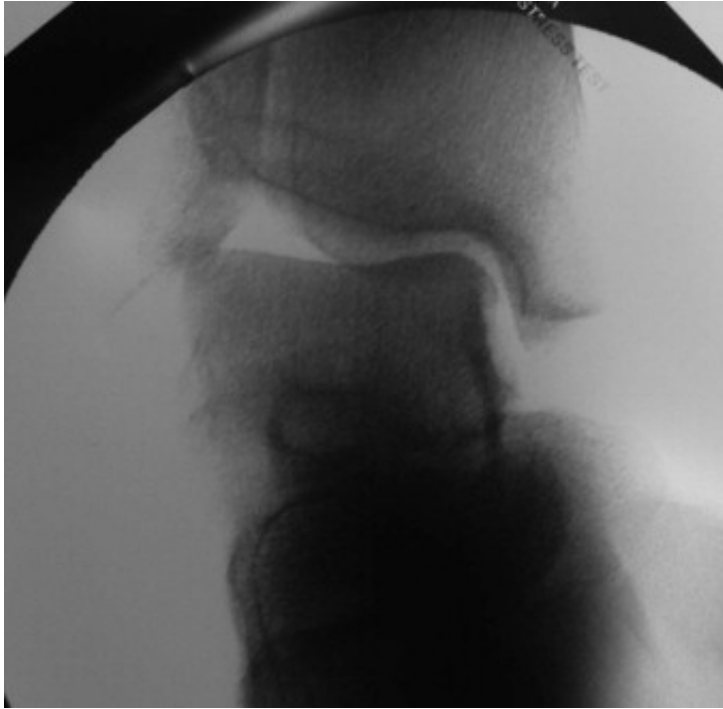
Stress radiograph.
